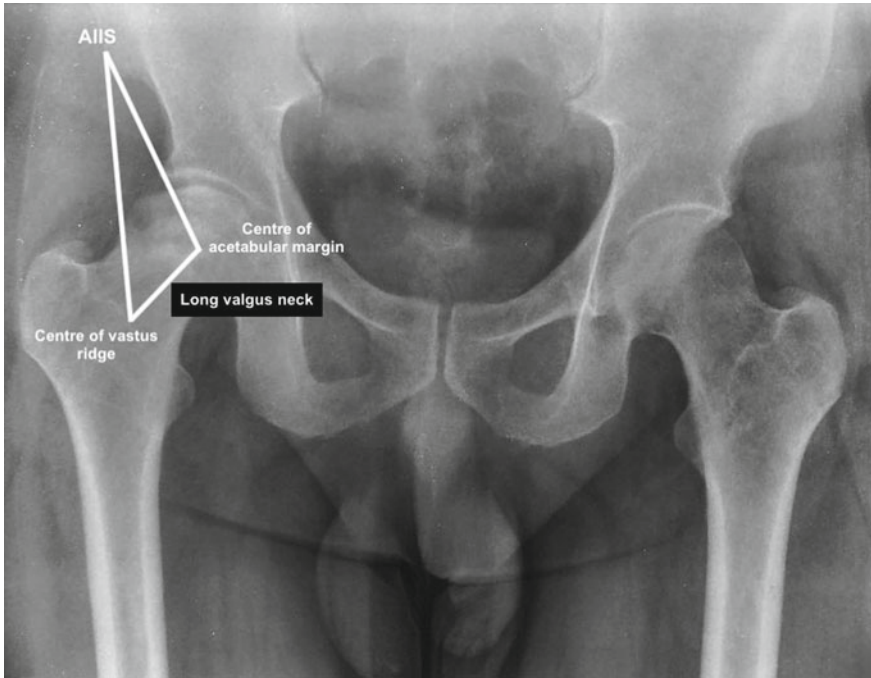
X-ray of both hips with pelvis in a patient with right hip AVN planned for THA by DAA. Note the long valgus neck as compared to Fig. 7.2 (varus neck). The MG triangle subtended with the base as the line joining the mid-point of vastus ridge and the mid-point of acetabular margin with Anterior Inferior Iliac Spine (AIIS) showing the working space for DA approach
